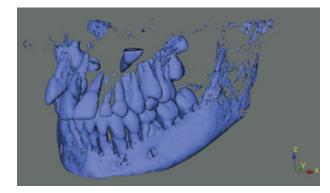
3D reconstruction of maxilla and mandible using cone beam CT data in Maxilim software, grossly ectopic 23 demonstrated, crown not completely viewed due to view height of CT scan.
